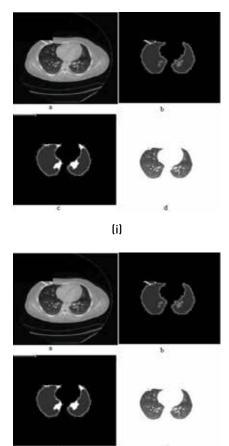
i) Result of watershed segmentation a) original CT image b)Segmented lung borders c)Smoothed lung Borders d) lung regions [7] ii) a) Original MRI of knee bone b), c) &d) are segmented images using clustering method with different parameters. [8]
